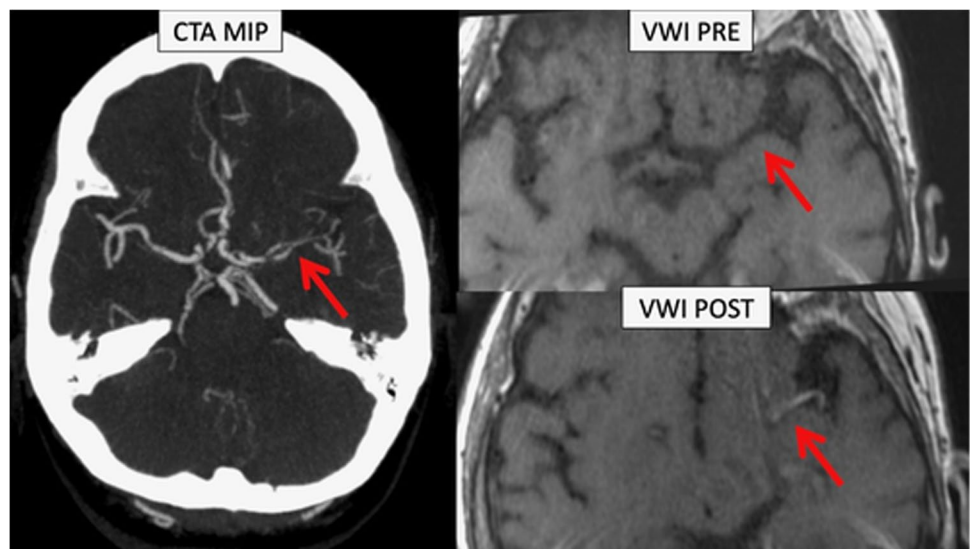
Left: CTA maximum intensity projection (MIP) image, annotated, demonstrating stenosis of early left MCA branching insular segments. Right: Annotated pre- (top) and post- (bottom) contrast MR vessel wall imaging demonstrating long segment concentric enhancement of the vessel wall compatible with vasculitis
